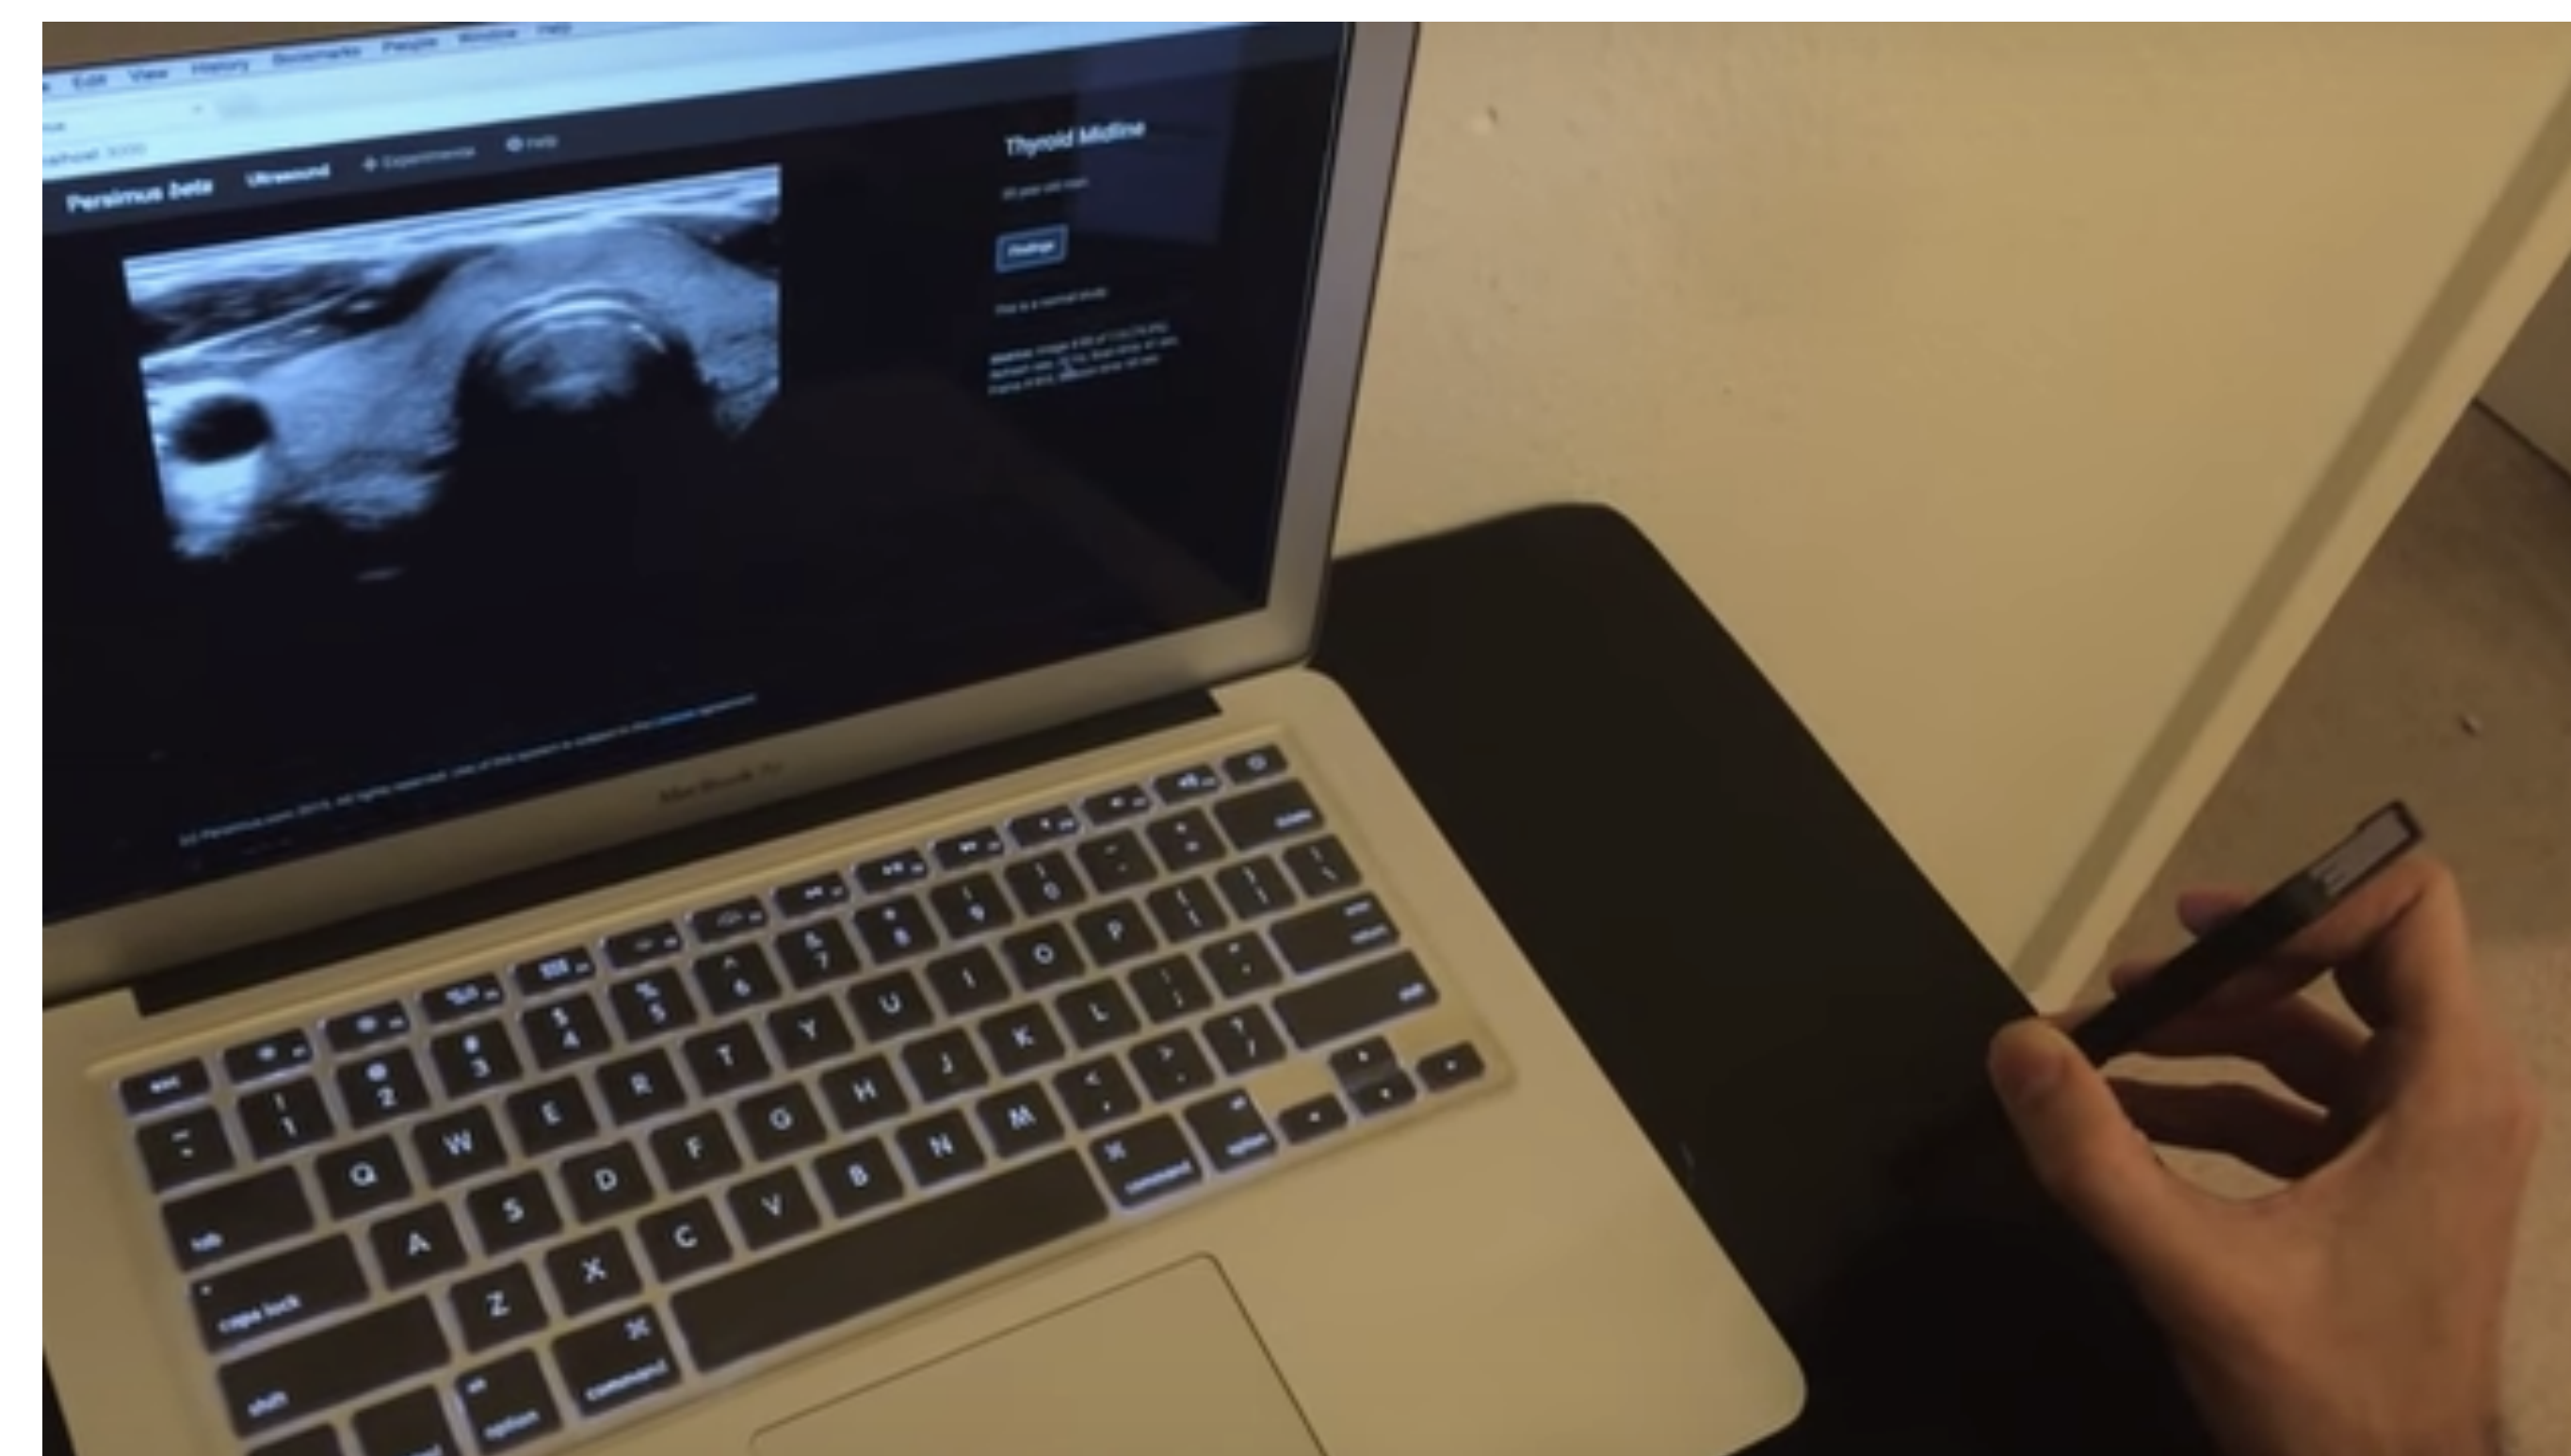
Image showing the Persimus program being used. The iPhone (right side of image) is the "mock transducer" and images are being displayed on a MacBook Air (left side of image), which is the "mock ultrasound display unit".
